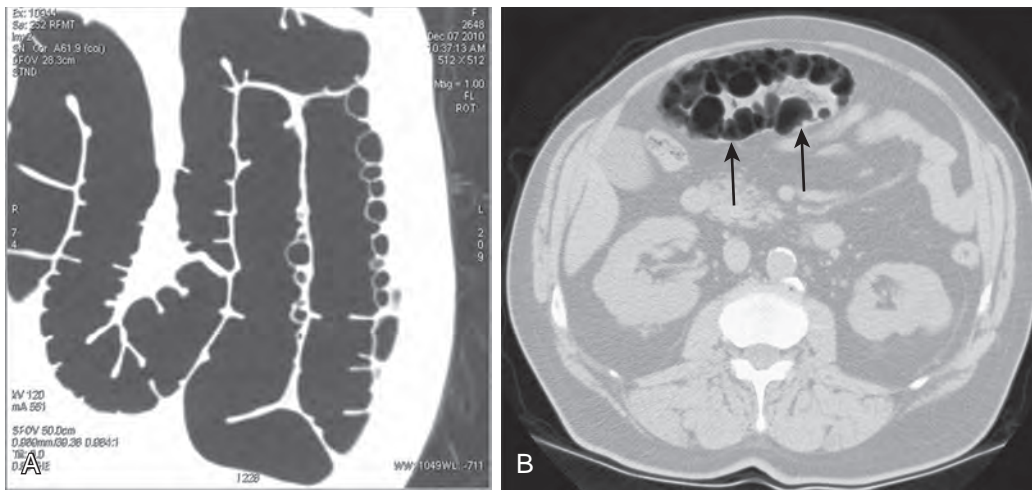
Primary pneumatosis cystoides intestinalis. A. Coronal reformatted image from a CT colonography study in an asymptomatic outpatient shows multiple intramural cystic lucencies. B. Axial imaging in another asymptomatic patient demonstrates multiple large gas-filled cysts (arrows), which produced scalloped defects in the transverse colon.
